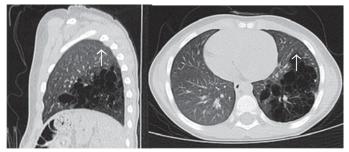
CT chest (sagittal view) - CPAM left lower lobe Fig.2b. CT coronal view - CPAM left lower lobe
